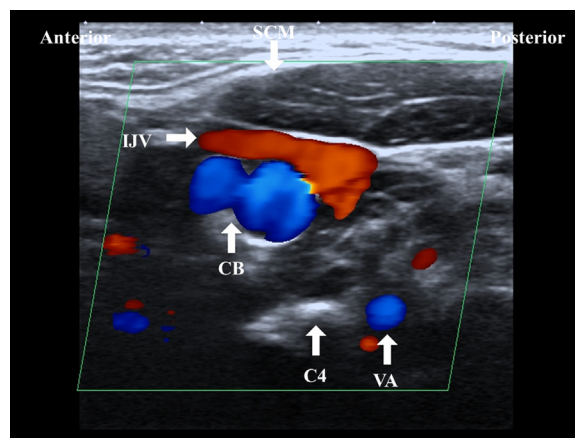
Transverse color Doppler ultrasound image of the neck at the C4 level. SCM, sternocleidomastoid muscle; IJV, internal jugular vein; CB, carotid bifurcation; VA, vertebral artery.
